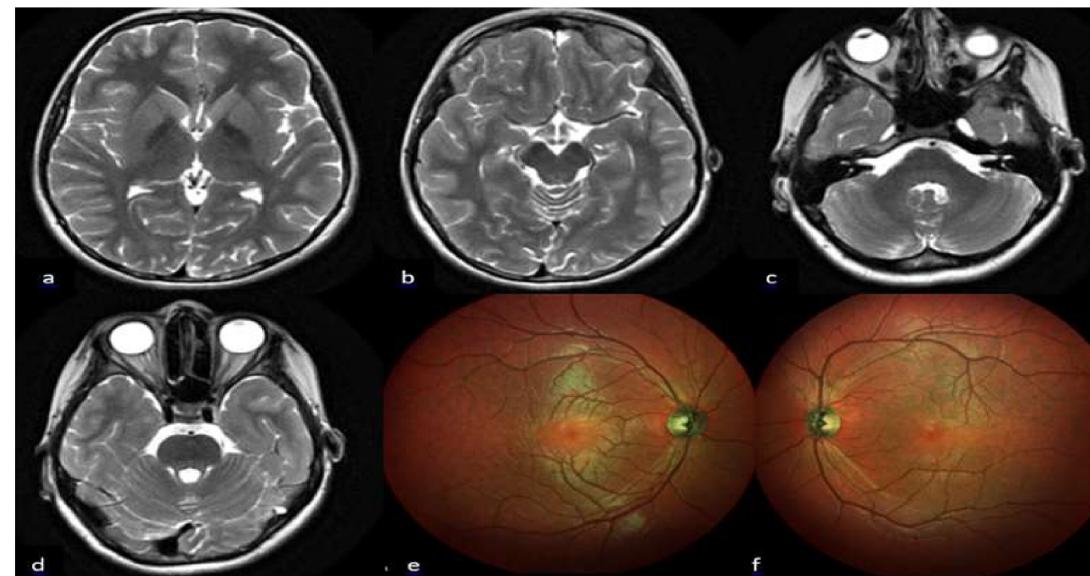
Cranial magnetic resonance imaging of Case 1, hypointensities in the globus pallidus (a), substantia nigra, red nucleus (b) and dentate nucleus (c), thinning of the optic nerves (d) on T2 weighted images. Optic atrophy on the right (e) and left (f) fundus photography.
